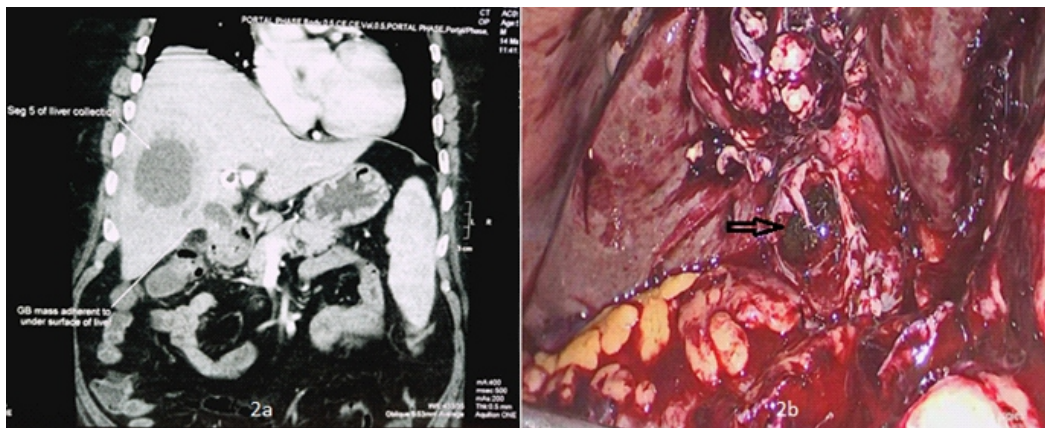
CT scan showing intrahepatic gall bladder with abscess in segment 5 of liver.
